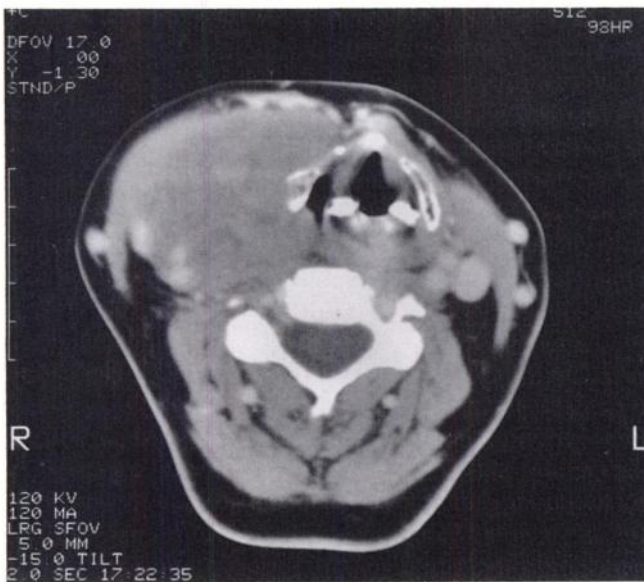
CT scan of the neck prior to treatment, showing a 13 × 6 cm mass in the right side of the neck, which appeared to involve or arise from the right lobe of the thyroid gland. A primary lymphoma of cervical lymph nodes could not, however, be excluded.
